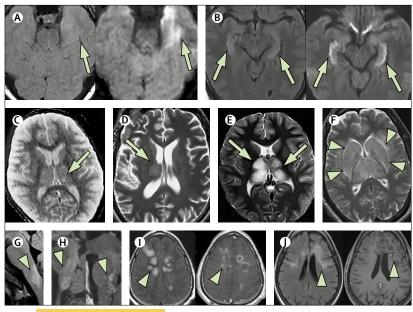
MRI findings in acute encephalitis
